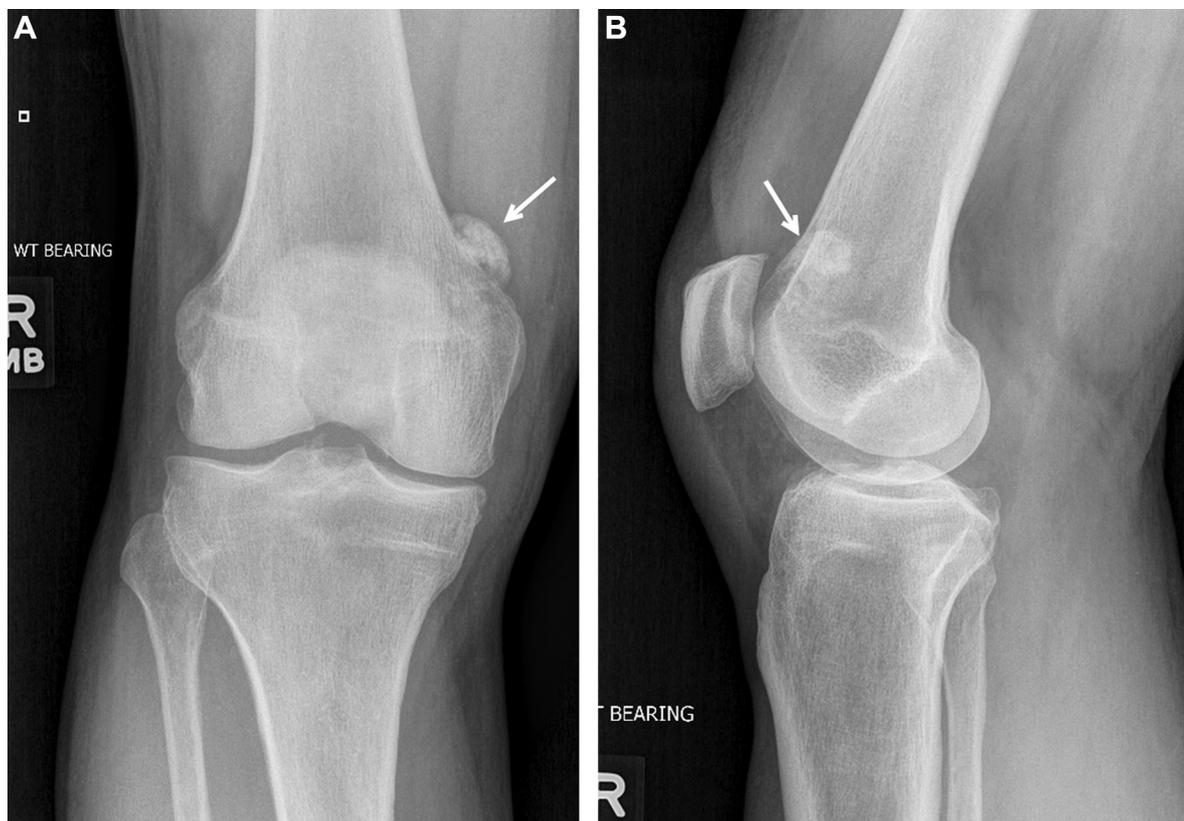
(A) Frontal and (B) lateral knee radiographs demonstrate an area of ossification (arrows) anteromedial to the medial femoral condyle. No underlying osseous involvement is identified.
